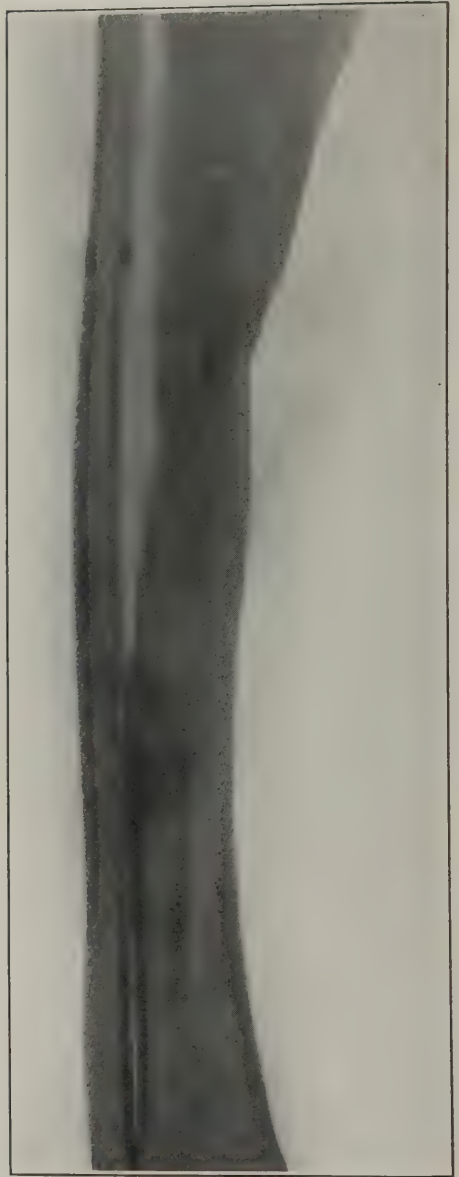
Case 3. Roentgenogram, July 28, 1922, 14 months after operation. There is excellent bony union
